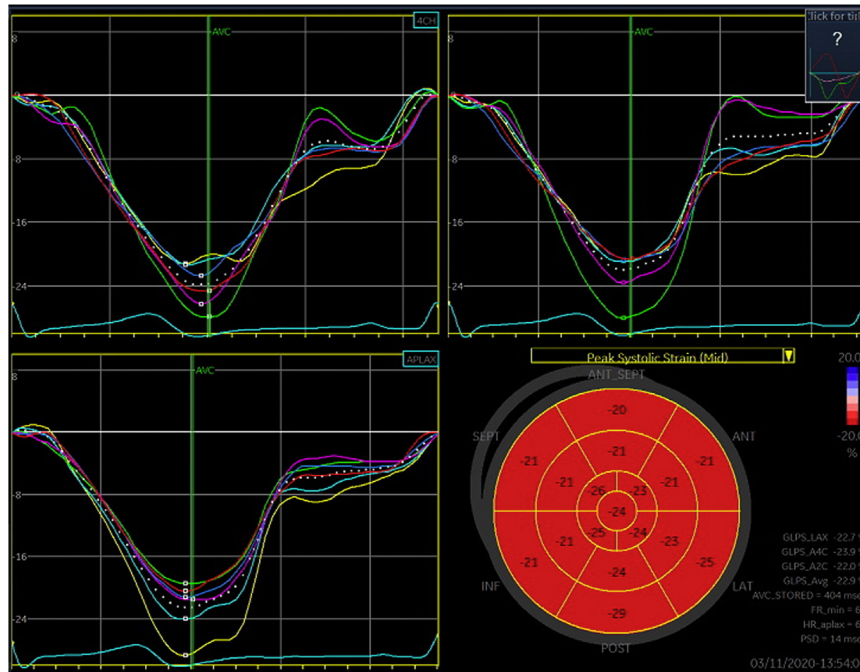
Global longitudinal strain. Normal global longitudinal strain (GLS) in a patient with chest pain. GLS = -22.9% and the bull-eye plot (lower right panel) is colored red, indication of normal LV function. The regional strain traces from six LV segment of the apical four-chamber (upper left), two-chamber (upper right), and long-axis (lower left) are shown.
